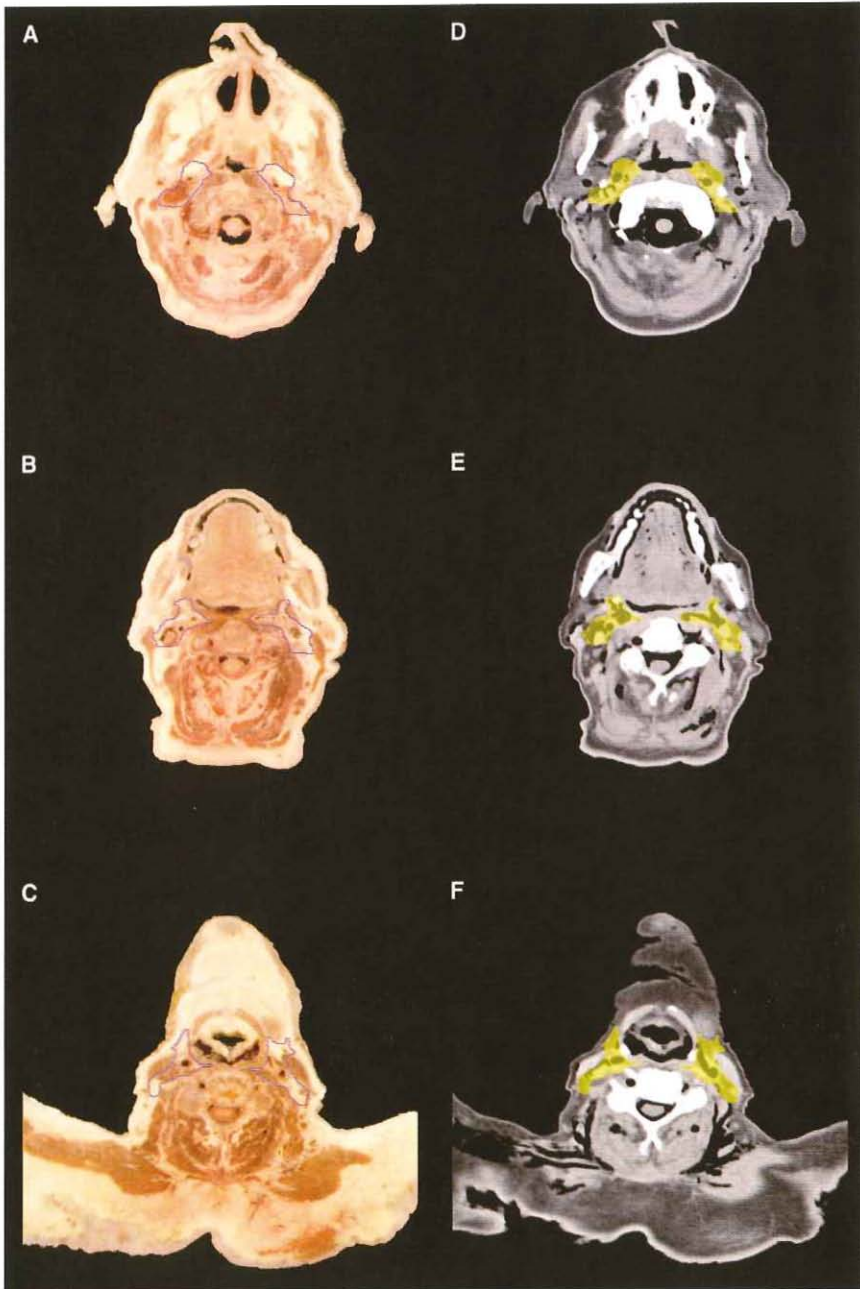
Region 2: borders are in blue outline on the anatomy slices (left) and in yellow color-wash on the CT slices (right).
